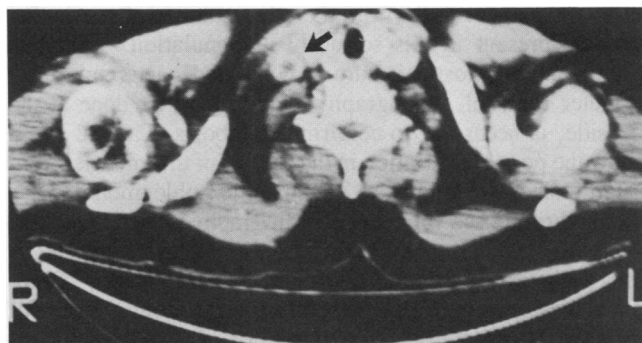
An intraluminal thrombus in case 1: Computed tomography of the upper mediastinum, with radiographic contrast, shows thrombus (arrow) in the right internal jugular-brachiocephalic vein segment.
